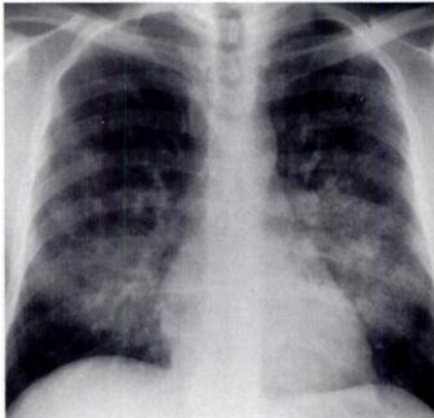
27-year-old man with diffuse pulmonary hemorrhage due to antglomerular basement membrane disease. Chest radiograph shows bilateral air-space consolidation with perihilar predominance. Lung apices and costophrenic angles are relatively spared.
